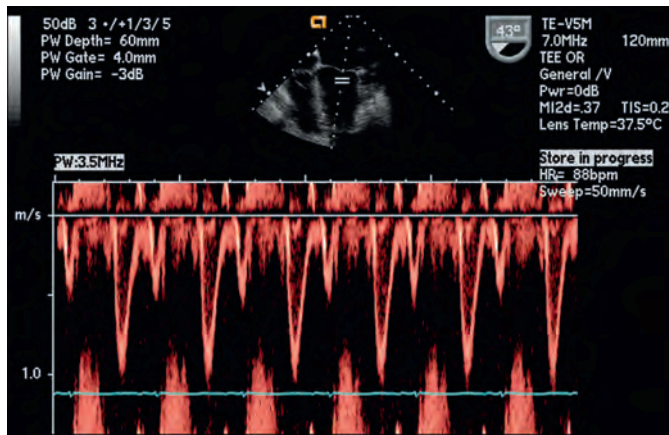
Mitral inflow Doppler echocardiography with E and A waves. HR, Heart rate; PW, pulsed wave; TEE, transesophageal echocardiography.
